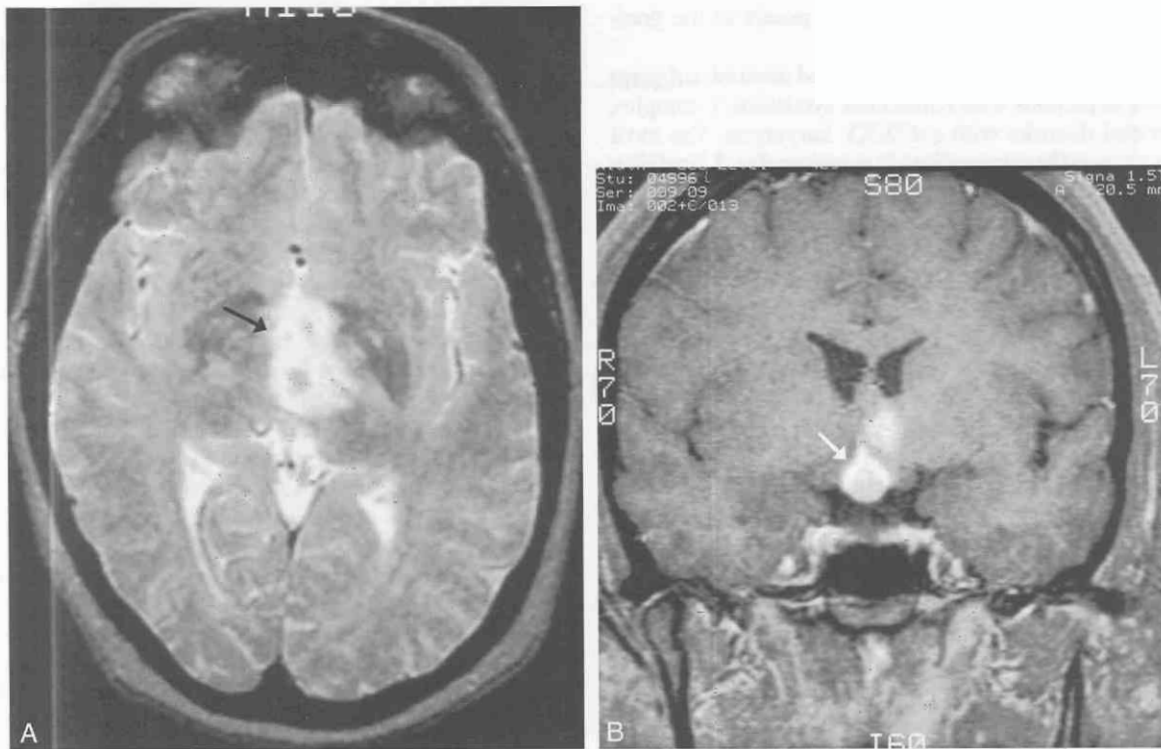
Langerhans cell histiocytosis of the hypothalamus and pituitary stalk. *A*, Axial T2-weighted MR image displays a large ill defined area of hyperintensity (likely representing edema) in the region of the hypothalamus (arrow). Within this hyperintensity can be seen two smaller isointense (with gray matter) foci. *B*, Coronal T1-weighted postgadolinium image demonstrates homogeneous contrast enhancement of the two foci; the larger lesion (arrow) extends into and widens the pituitary stalk.
